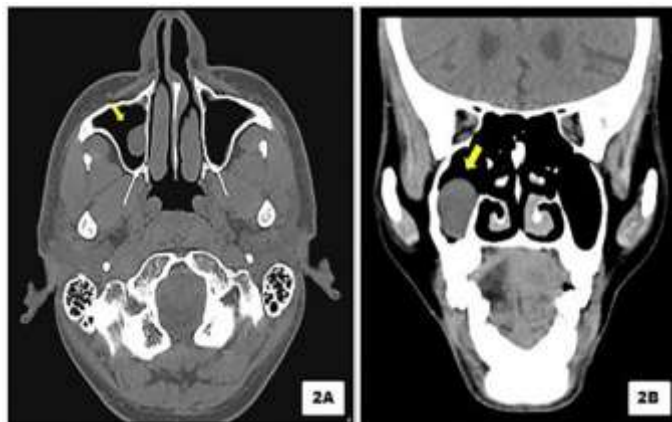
Computed Tomography scan - axial view (Fig. 2A) and coronal view (Fig. 2B) shows unilateral presentation of polyp in maxillary sinus (yellow arrow)
